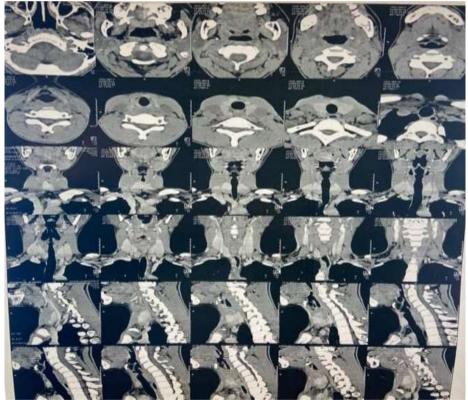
CT appearance of esophageal stenosis: Stenosing wall thickening, eccentric of the esophagus entrance
